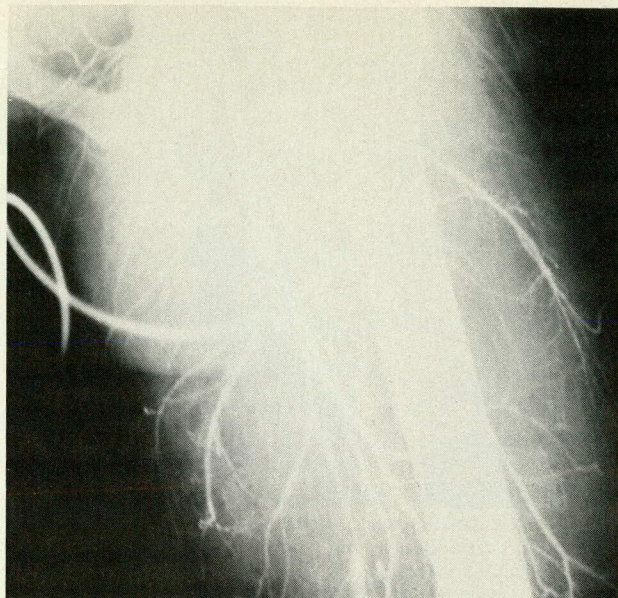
X-ray demonstrates obstruction of the right superficial femoral artery in the upper portion of the thigh.
